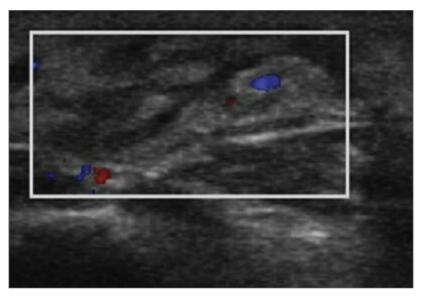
Doppler image shows vascularity in the hyperechoic region
